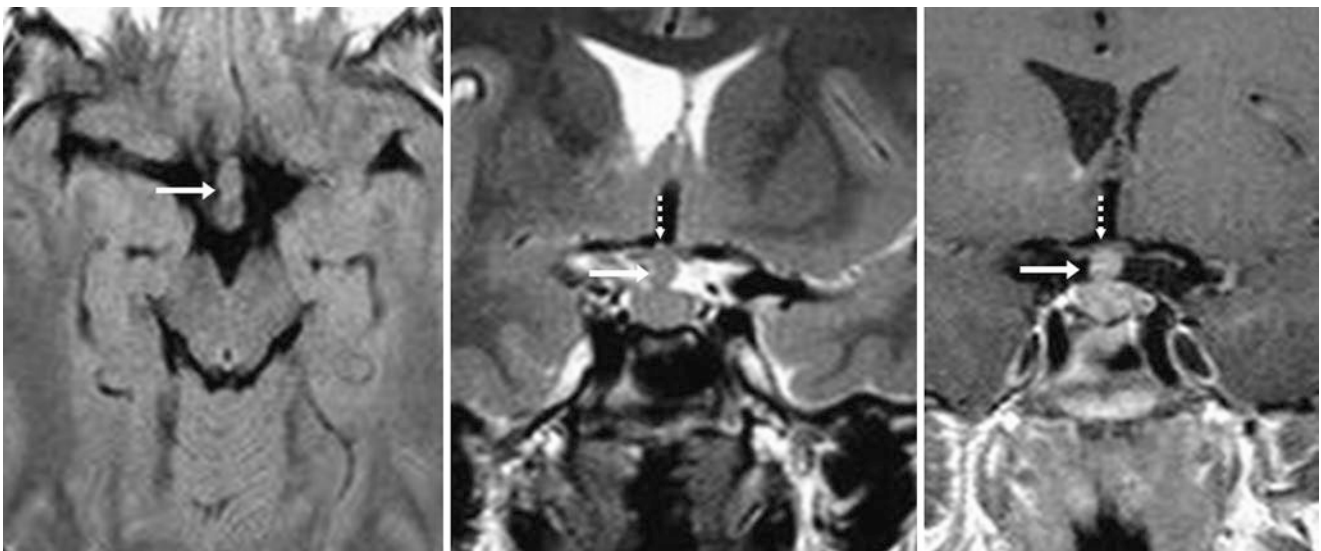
Comparison case of lymphocytic hypophysitis (biopsy proven): A 16-year-old male with growth delay; a 1.5 T MRI depicts moderate enlargement of the stalk (*arrows*) on noncontrast axial FLAIR
